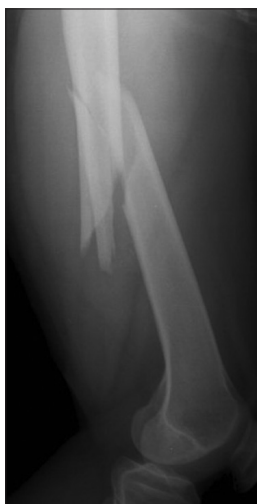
Radiograph of right femur showing fracture shaft femur
